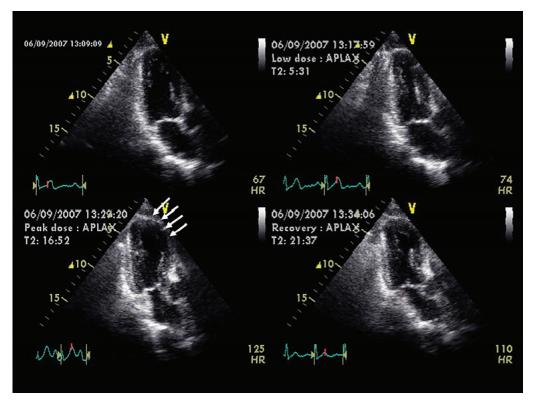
Dobutamine stress echocardiography. Quad-screen format of apical 3-chamber view, end-systolic frames at baseline (upper left), low dose (upper right), peak dose (lower left) and recovery (lower right). At low dose, there is increased systolic wall thickening in all segments indicating improvement in contractility. At peak dose, akinesis of distal septum and apex can be noted; arrows indicate region with absent wall thickening, consistent with ischemic response.
